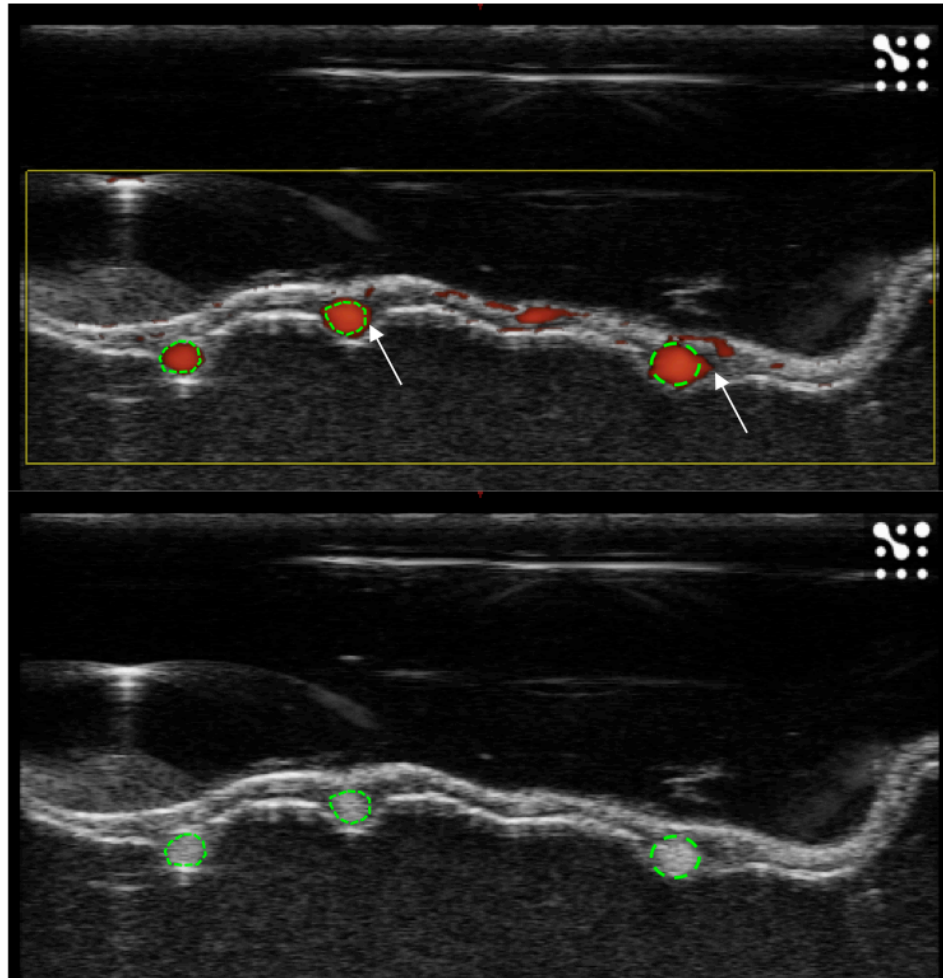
Blooming artifact in a power Doppler image. Color “bleeds” (marked by white arrows) outside vessel boundaries (dashed green line) produced by manually segmenting vessels from B-mode image (lower image).
